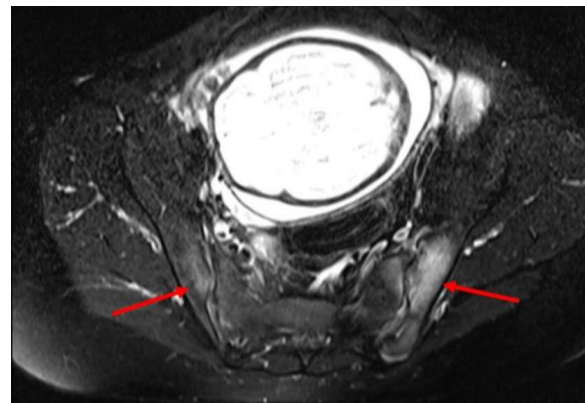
MRI STIR image showing hyperintensity in ilium, representing sclerosis
